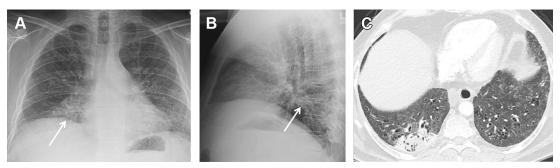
(A) PA chest demonstrates bilateral diffuse hazy opacities and low lung volume thought to be related to patient's known non-specific interstitial pneumonia (NSIP). Focal opacity in the right lower lobe (arrow) was not recognized. (B) Lateral chest radiograph shows positive spine sign (arrow), absence of normal progressive lucency over the lower thoracic vertebral bodies, which was not recognized. (C) Chest CT performed months later demonstrates bilateral groundglass opacities and traction bronchiectasis consistent with NSIP and a right lower lobe consolidation, eventually proven to represent adenocarcinoma. The lung cancer was missed on chest radiograph due to satisfaction of search and failure to recognize the "spine sign" on the lateral chest radiograph.
